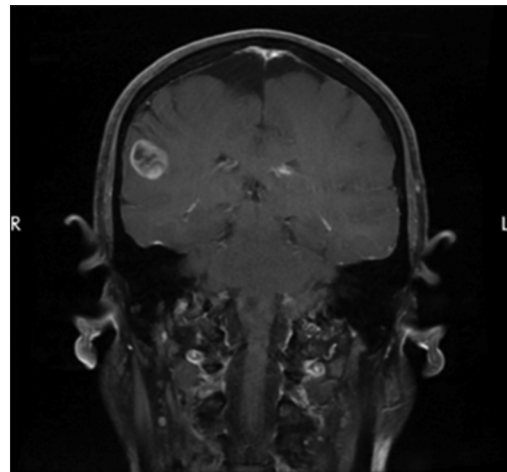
Magnetic resonance imaging brain T1 with and without contrast, coronal section of the brain showing a ring enhancing lesion in the right parietal lobe
